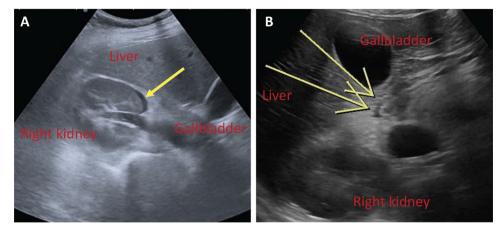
(A, B). Abdominal ultrasound scans. Minimal perirenal (1A) and periduodenal (1B) fluid (yellow arrows).
